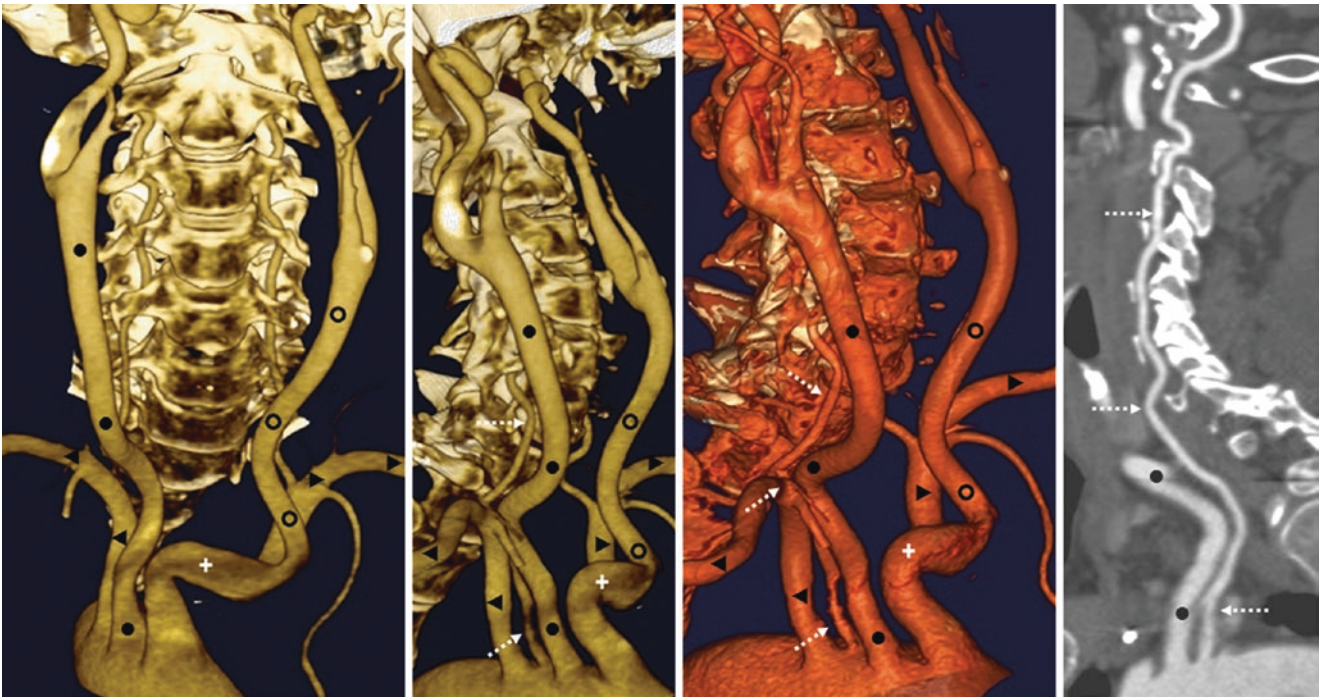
62-year-old with an asymptomatic “mirror image” right-sided aortic arch (from Kartagener’s syndrome with situs inversus) on a 3D VR CTA, with AP (*left*) and right anterior oblique (RAO) views (*left middle* and *right middle*). Also, a curved oblique sagittal MPR (*right*) demonstrates that the right vertebral artery (*dotted arrows*) arises
